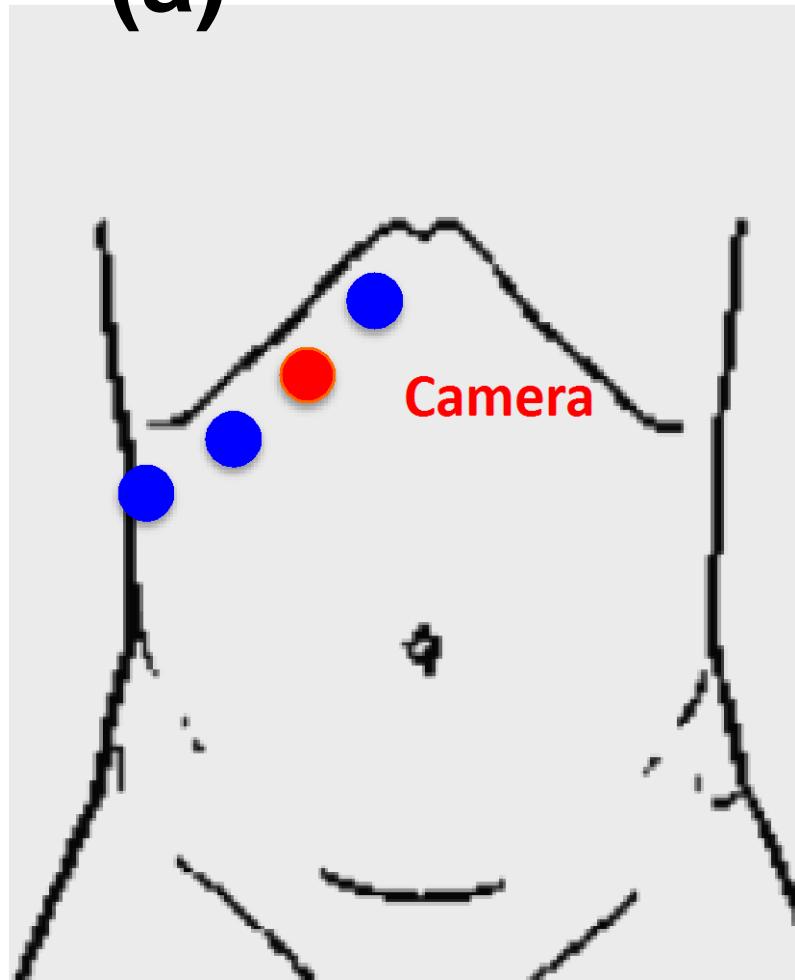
A 36-year-old female was incidentally found to have a 4.8-cm tumor located in the right renal hilar area (a: CT, blue arrow). Laboratory investigation findings were normal, and the preoperative diagnosis was a benign neurogenic tumor. In this location, rotating the kidney was helpful to approach the tumor (See Video clip 2). RRV=Right renal vein.
